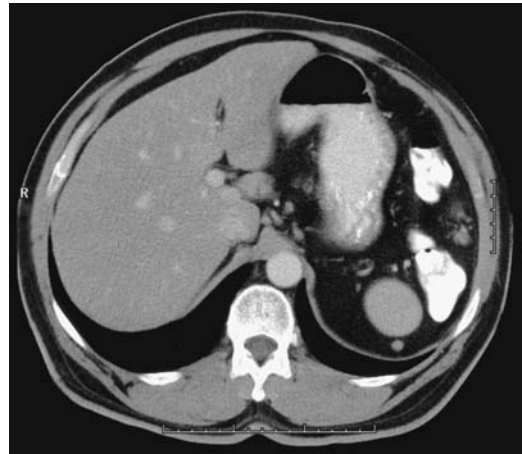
Splenosis. The patient had a splenectomy as a child due to trauma. Computed tomography (CT) reveals left upper quadrant soft tissue nodules. Serial studies showed no change. (Courtesy of Patrick Fultz, M.D., University of Rochester.)
